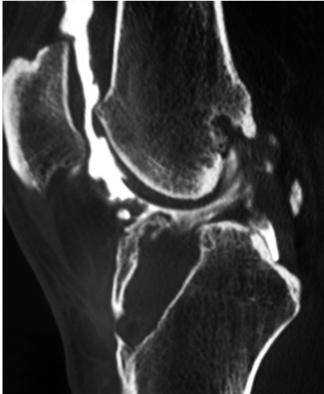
A sagittal CT image of a knee demonstrating enlargement of the ACL tibial tunnel
